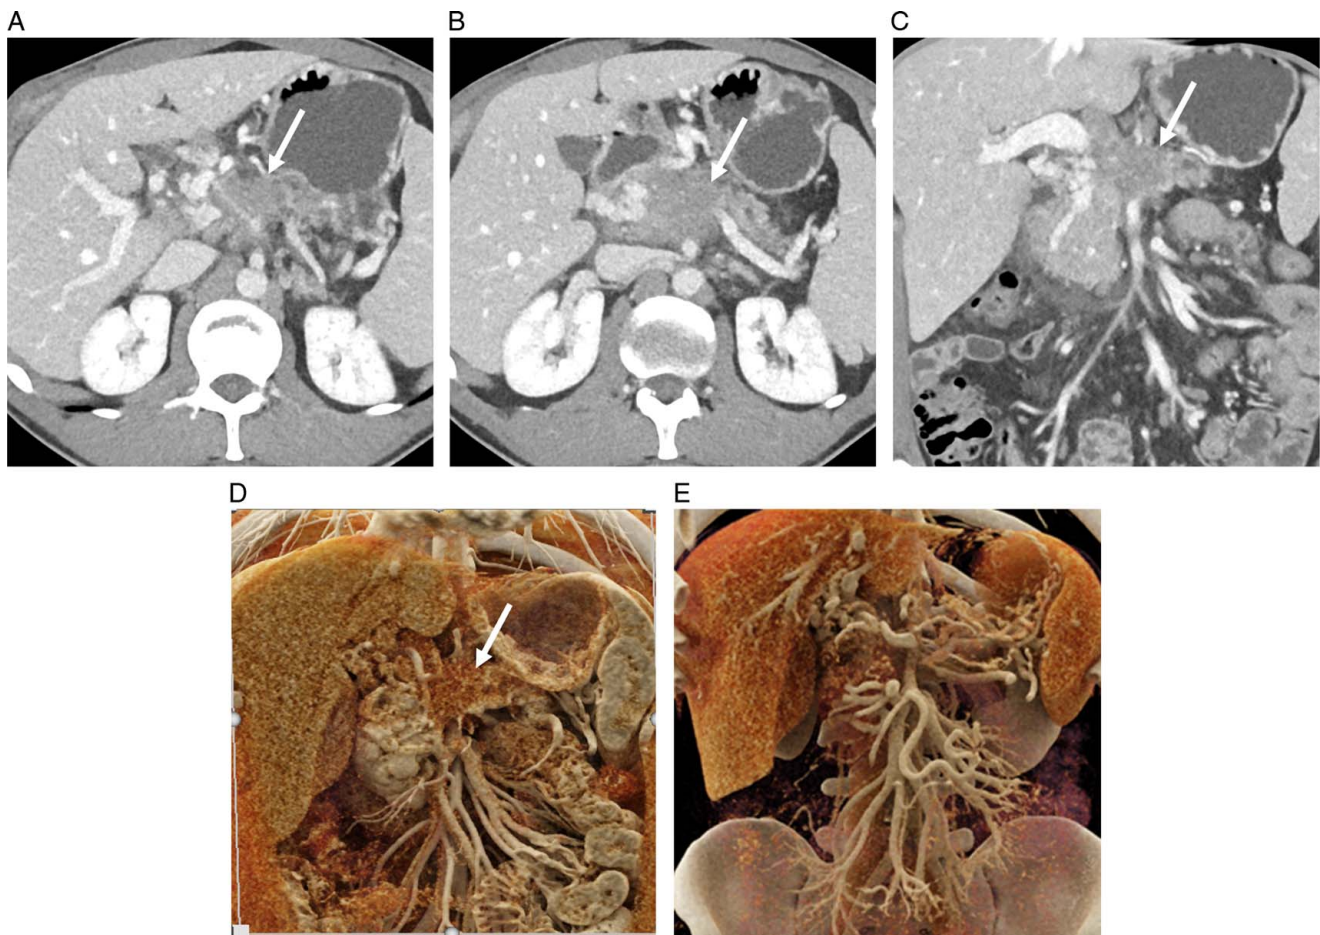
A 36-year-old man with locally advanced pancreatic ductal adenocarcinoma. Axial (A and B) and coronal (C) intravenous (i.v.) contrast-enhanced computed tomography (CT) images in the portal venous phase showed an infiltrative hypoenhancing mass arising from the pancreatic neck and proximal body (arrows) with encasement of the celiac artery, superior mesenteric artery, portal vein, and superior mesenteric vein, with chronic portal vein occlusion and prominent venous collaterals. Cinematic rendering of coronal i.v. contrast-enhanced CT images in the portal venous phase (D and E) again showed extensive tumor encasement with prominent vascular collaterals. The tumor was staged as locally advanced, and the patient was treated with systemic chemotherapy.
